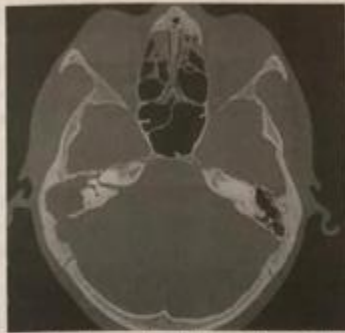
HRCT showing erosion of horizontal part of facial nerve along with erosion of sigmoid sinus plate on right side.
